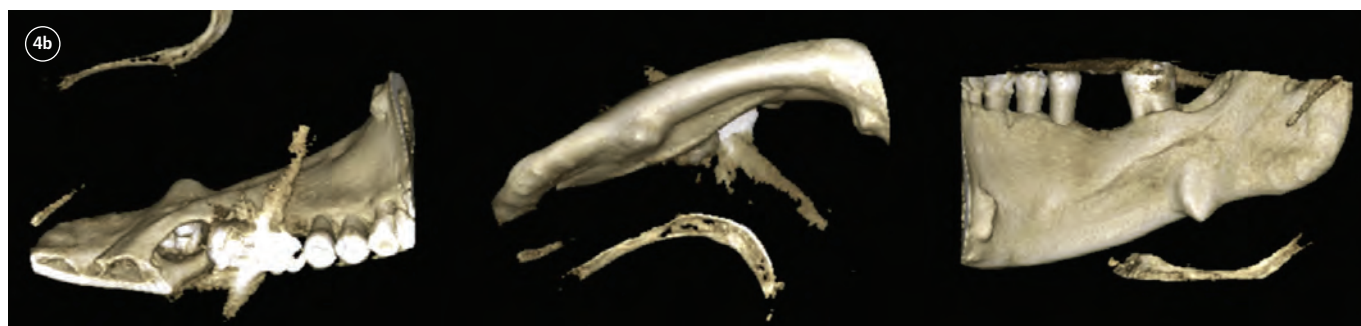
3D CBCT images in three views.
